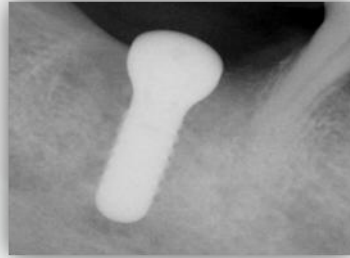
6-Week Post-Operative Radiograph
